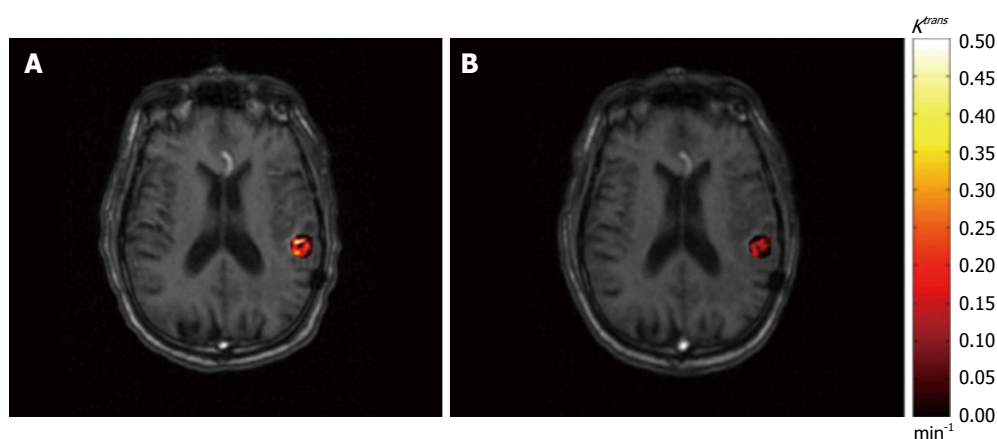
An example of permeability rate constant K^{trans} map derived from dynamic contrast-enhanced imaging. The pre-treatment (A) and post-treatment (B) K^{trans} results within gross tumor volume are superimposed on axial T1-weighted magnetic resonance images.
